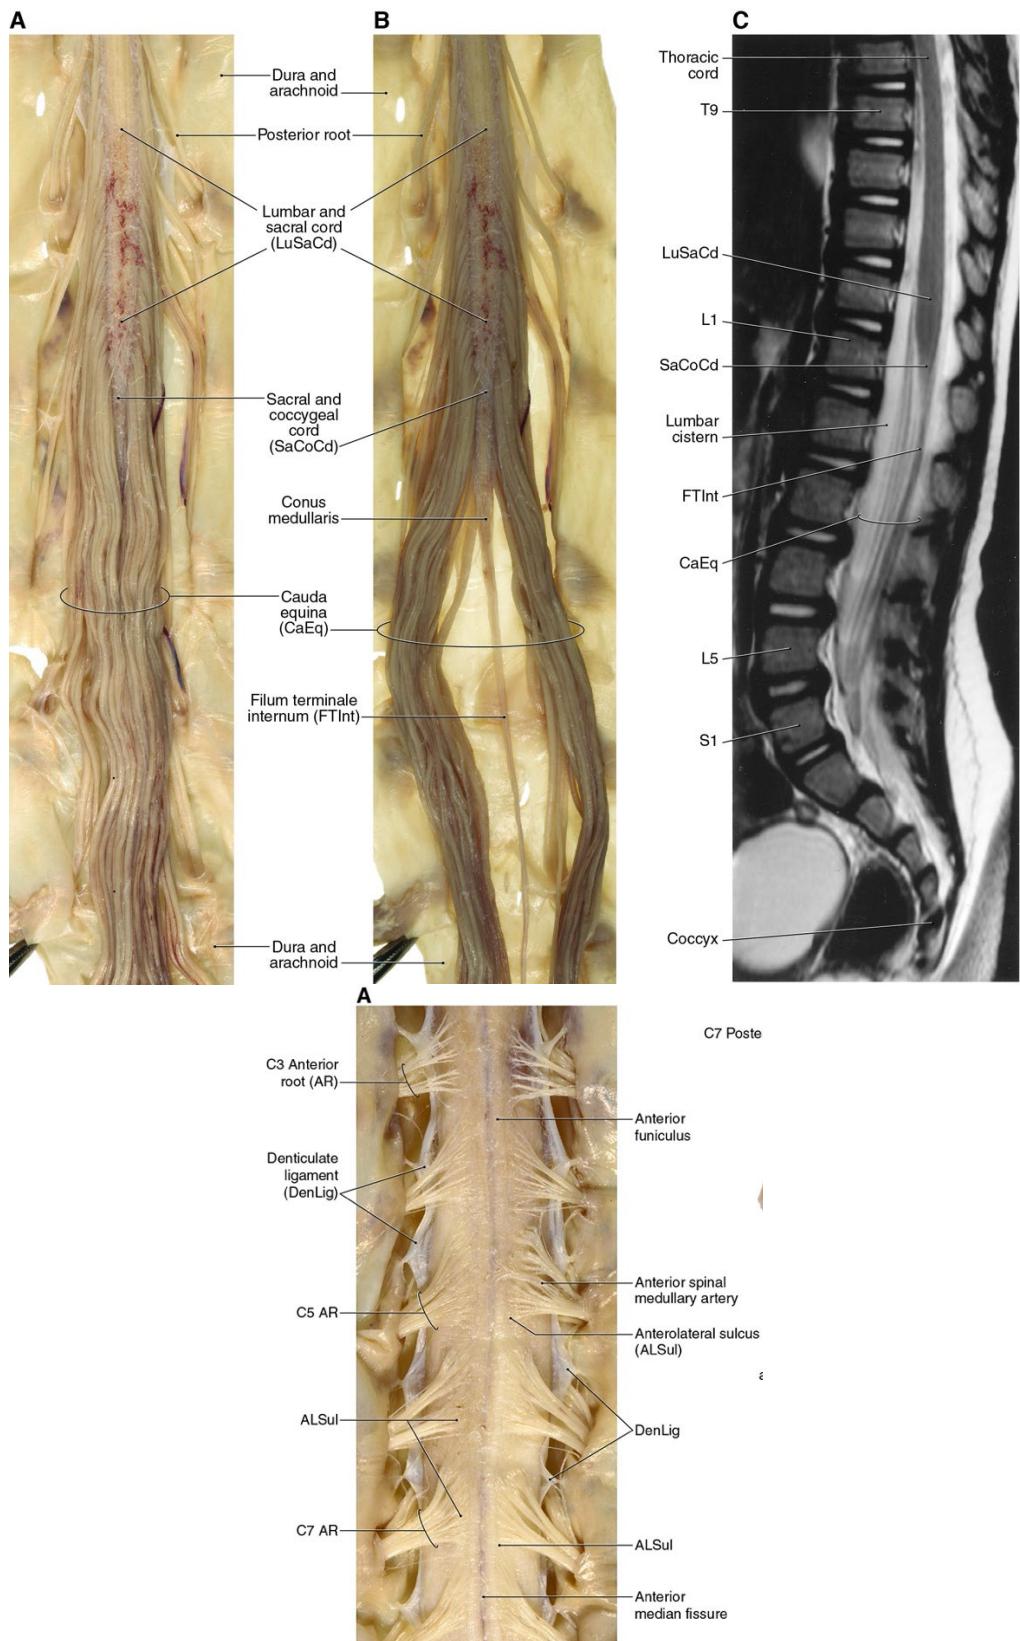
Top image: Overall posterior (A, B) and sagittal MRI (C, T2-weighted) views of the lower thoracic, lumbar, sacral, and coccygeal spinal cord segments and the cauda equina. In A and B, the dura and arachnoid mater have been reflected to better identify the filum terminale created by the pia mater. Bottom image: anterior view of cervical spinal cord with the dura and arachnoid mater reflected to see the denticulate ligaments formed by the pia mater. (Figures 2-4. and 2-2 Neuroanatomy Atlas in Clinical Context: Structures, Sections, Systems, and Syndromes. 10<sup>th</sup> edition)
